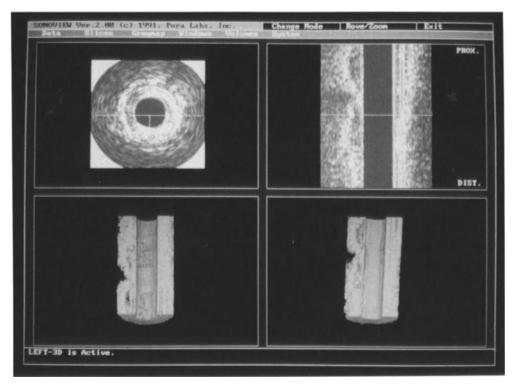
Computer-enhanced three-dimensional reconstruction from two-dimensional ultrasound. (Courtesy of Image-Comm Systems, Incorp., Sunnyvale, CA.)
